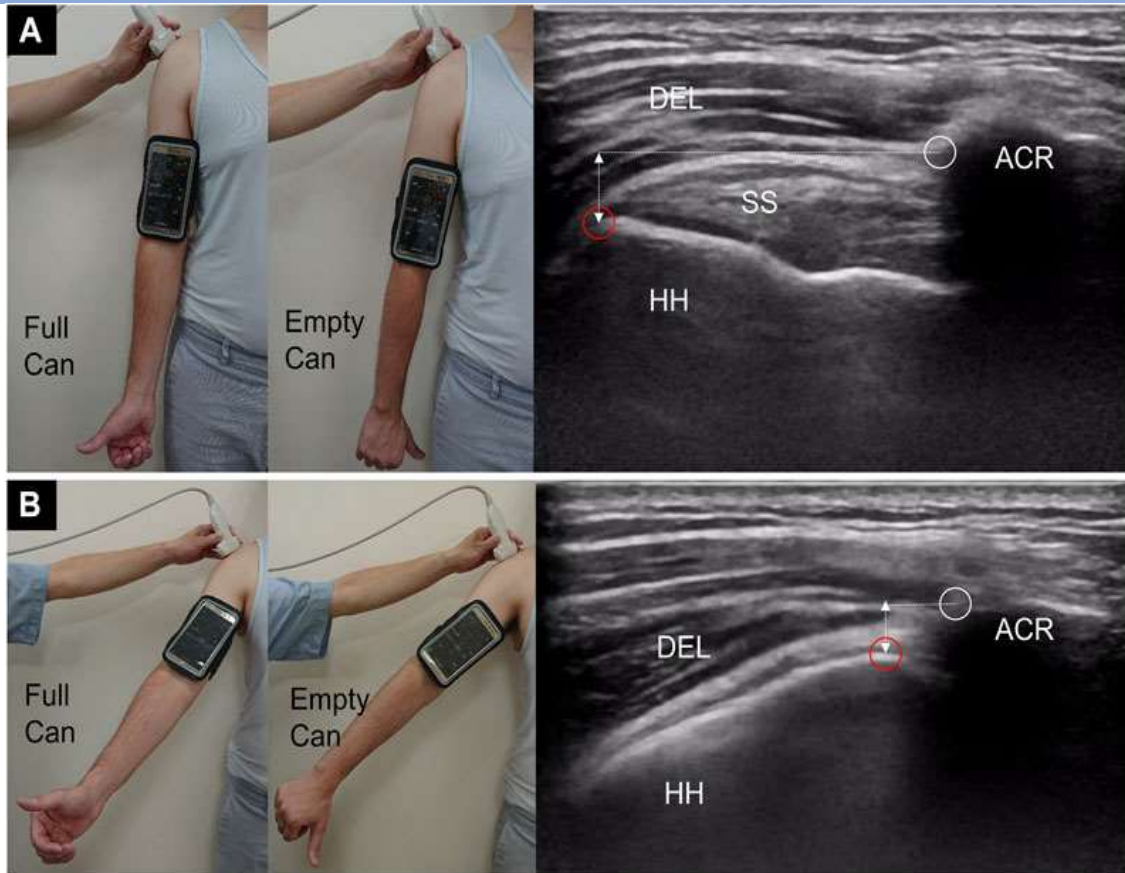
The subacromial region and the upper limb's posture can be imaged using ultrasound in both the abducted (B) and beginning (A) positions. In (B), the larger tuberosity is about to pass the lateral acromial margin, which is represented by the white circles. humeral head (HH), supraspinatus tendon (SS), and acromion (ACR) are all shown by the vertical dashed line (46).
